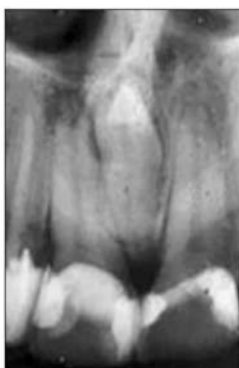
Periapical radiographs of single and multiple mesiodens.
